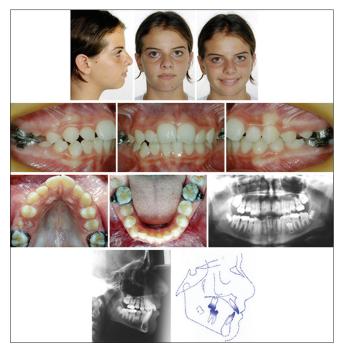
At 8 years 10 months. Progress photographs, panoramic and cephalometric radiographs, and cephalometric tracing
